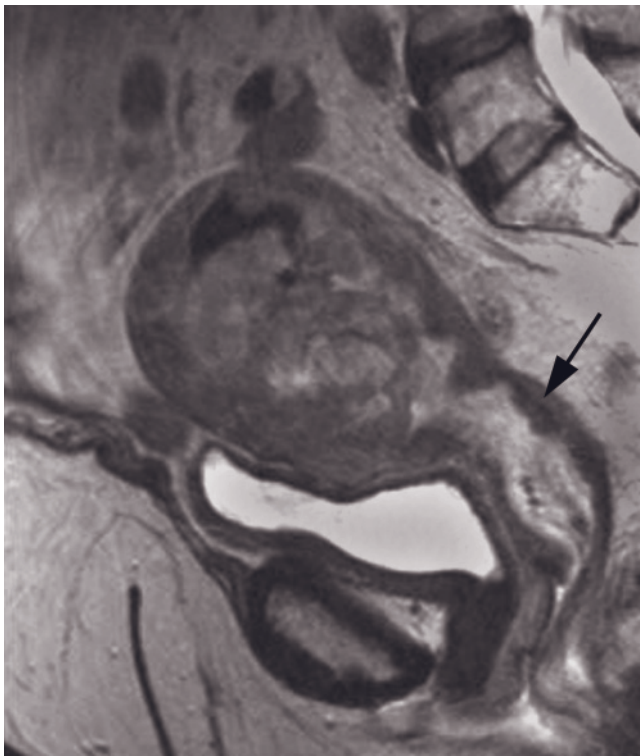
Endometrial carcinoma, extensive disease. Sagittal (a, b) and transverse (c) T2-weighted ETSE and gadolinium-enhanced fat-suppressed SGE (d) images show a large necrotic endometrial mass with invasion of the posterior wall of the urinary bladder (arrows, a-c) as well as extension to the left pelvic sidewall (arrow, d). This mass extends to the sigmoid colon and rectum (curved arrow, a). Liver metastases (not shown) were also identified.
